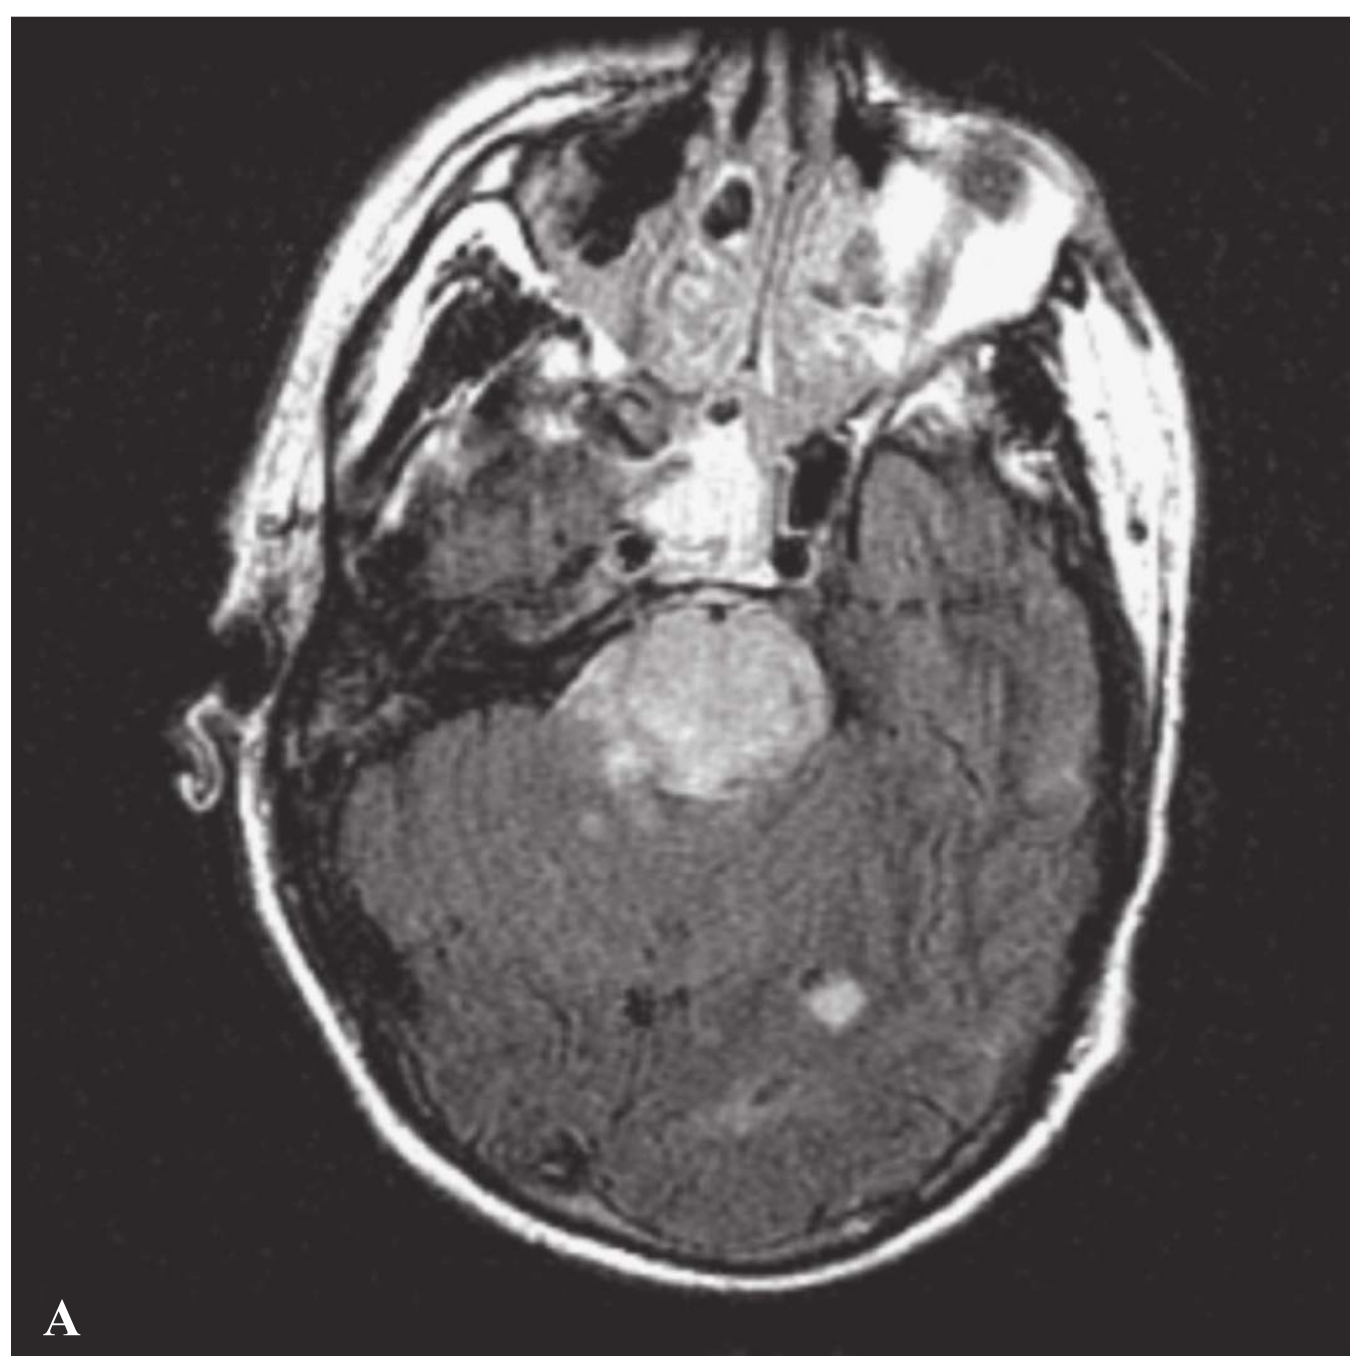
Locked-in syndrome. Axial FLAIR sequence MRI of the brain demonstrating a massive pontine infarction in a 46-year-old man with locked-in syndrome secondary to basilar artery thrombosis (A). Cerebral angiography demonstrating thrombus in the distal basilar artery (B).
